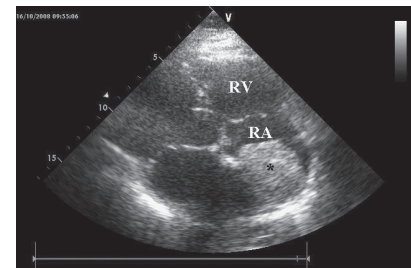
Modified 4-chamber view during transthoracic echocardiography (RA=right atrium, RV=right ventricle, asterisk showing myxoma).
